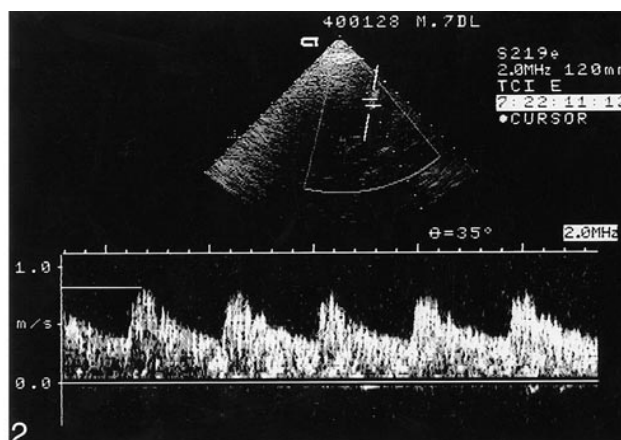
Representative waveforms at the onset of contrast effect and at peak enhancement. Note the marked enhancement of the Doppler spectrum after the administration of contrast material and the apparent increase in PSV after the administration of contrast material compared with before.
